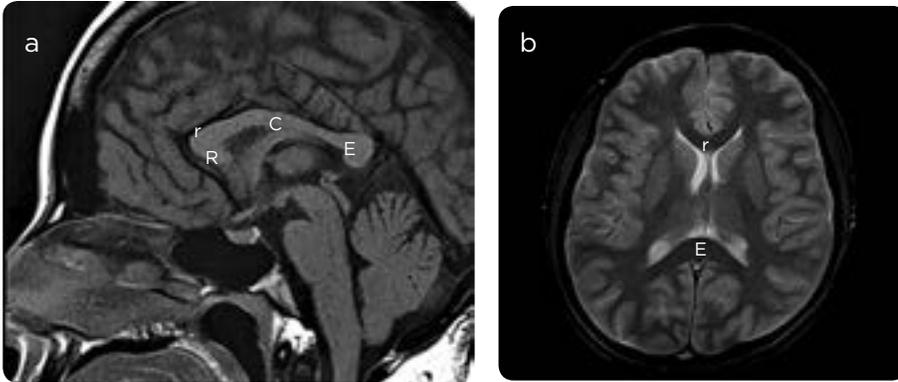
a) Sagittal MRI with T1 information. Normal corpus callosum. R: face, r: knee, C: body, E: splenii. b) Axial MRI with T2 information: r: knee, E: splenium.
